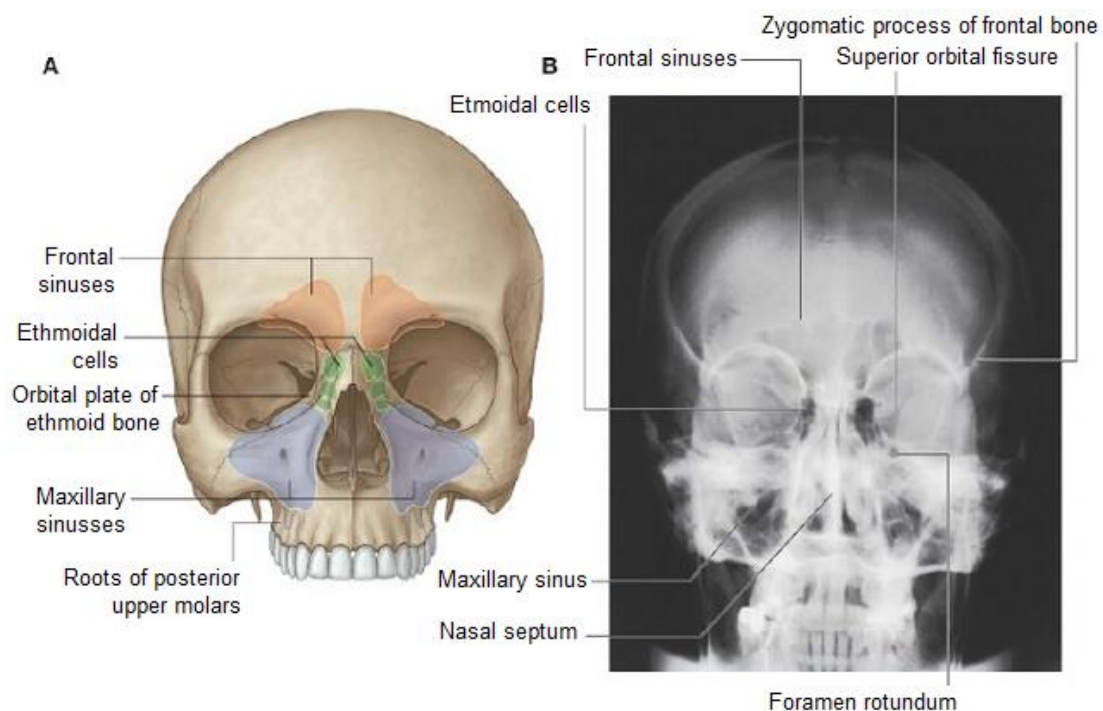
Paranasal sinuses. A – Anterior view. B – Posteroanterior skull radiograph.
